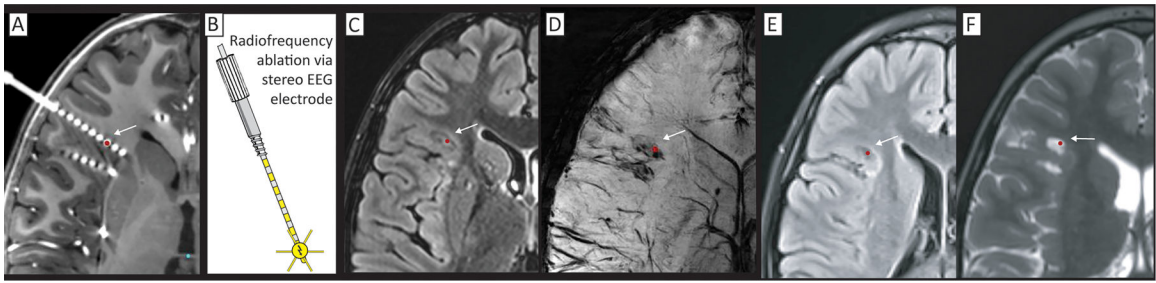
Radiofrequency ablation (RF) through stereoelectroencephalography electrodes. (A) Seizure onset was identified by SEEG in several of the deepest contacts, centered at the red dot, and indicated by an arrow (on CT fused to gadolinium-contrasted T1). (B) RF ablation is performed by passing current directly through the SEEG electrodes, using a grounding pad on the leg. (C-D) Immediate post-procedure MR imaging on T2 FLAIR (C), and susceptibility-weighting (D). (E&F) 16-month post-procedure T2 FLAIR (E) and standard T2 (F) showing persistent lesion effect.
